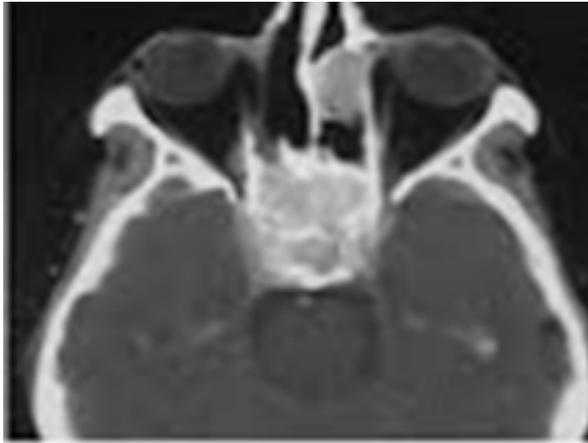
CT Delineating Mass With Minimal Erosion.
